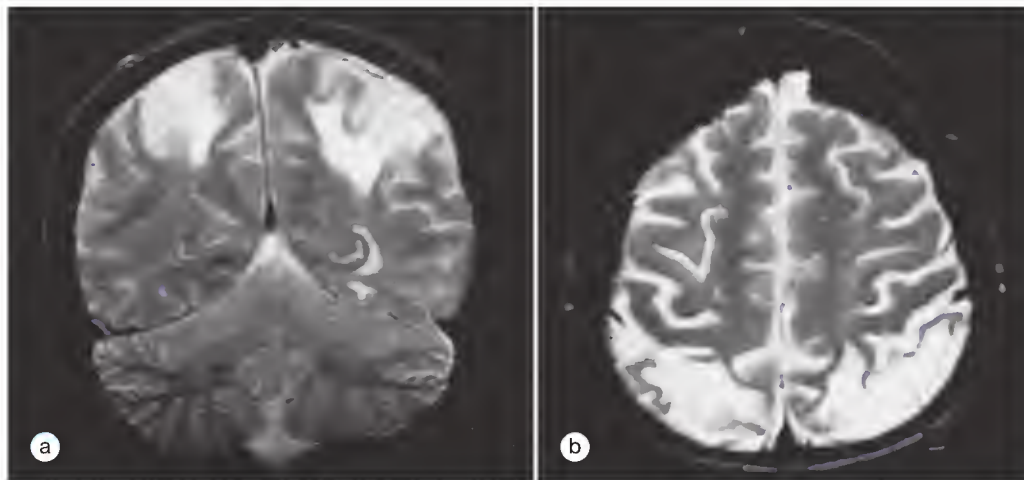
Demonstration by magnetic resonance imaging of biparietal infarctions in a 26-year-old woman with antiphospholipid syndrome. This woman also had a right frontal lobe infarct, which is not shown here. She had no risk factors for thrombosis other than positivity for the lupus anticoagulant and high-positive results on assays for immunoglobulin G anticardiolipin antibodies. Her first pregnancy ended in intrauterine fetal death at 24 weeks' gestation.
